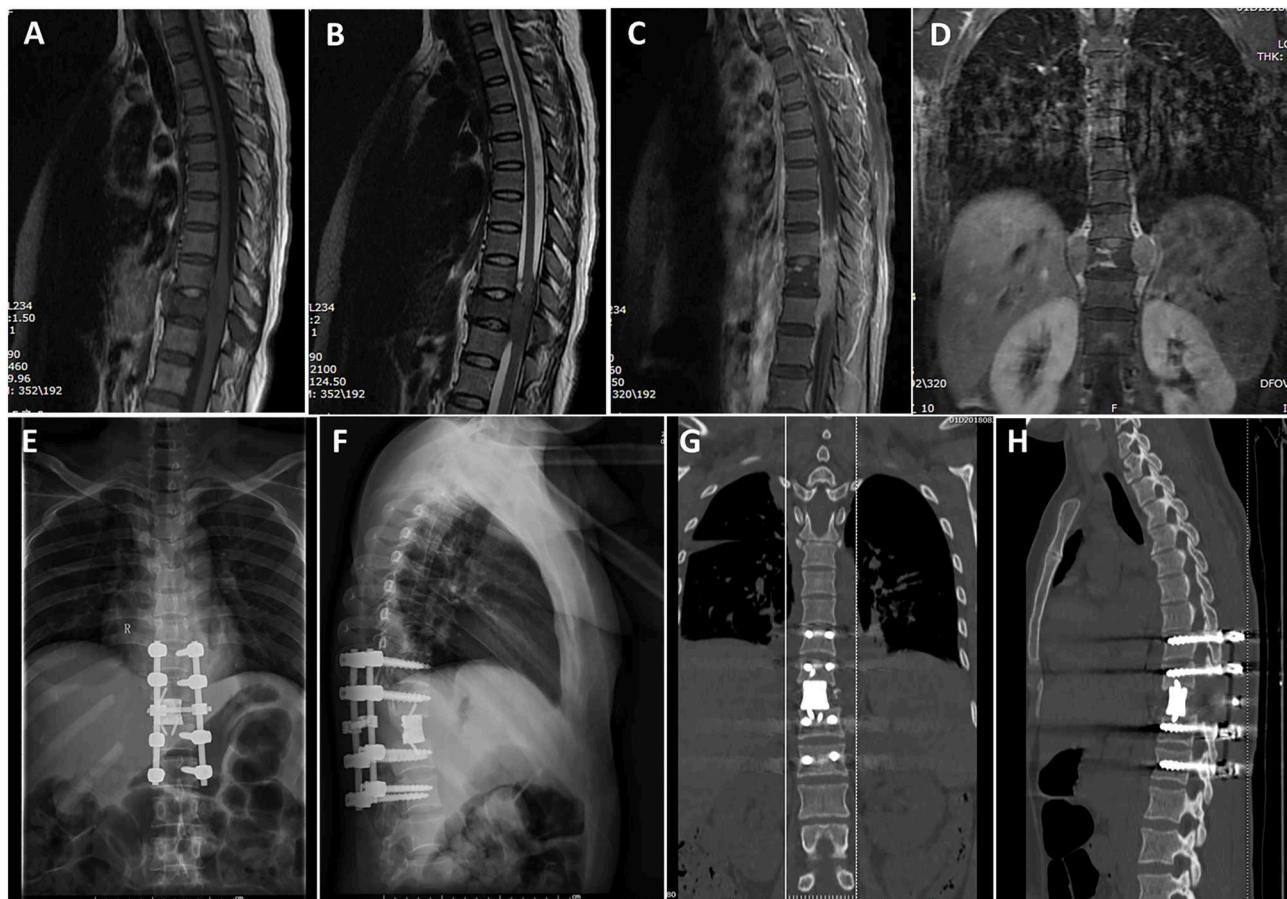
A case labeled as spinal canal type because the maximal diameter of the tumor was located in the spinal canal. Preoperative T1-weighted (A) and T2-weighted (B) images revealed a tumor at the T10–12 level. Contrast-enhanced sagittal (C) and coronal (D) images revealed that the tumor showed heterogeneous enhancement. Postoperative X-ray showed sound reconstruction by a 3D printed microporous titanium vertebral body and posterior screw-rod system. Anterior-posterior view (E). Lateral view (F). Postoperative computed tomographic scan of the thoracic spine 1 year after surgery showing excellent spinal fusion and the absence of tumor recurrence. Coronal section image (G). Sagittal section image (H).
